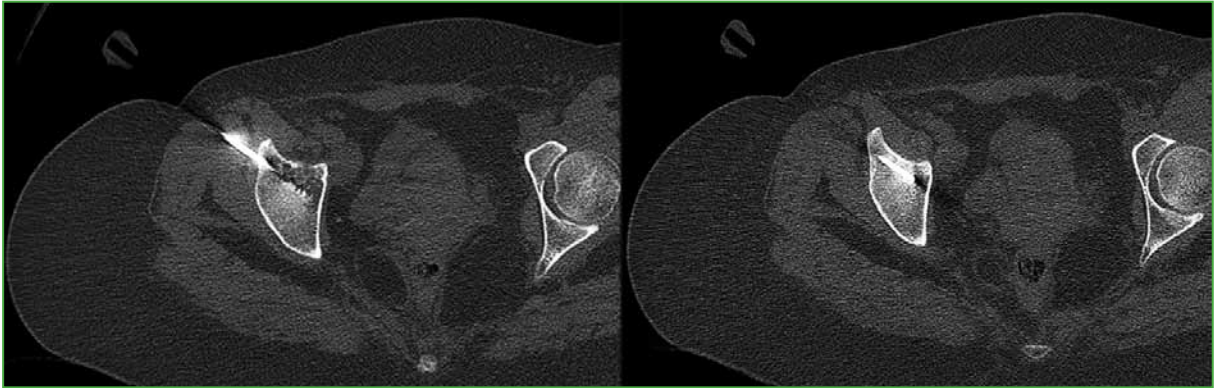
CT-guided biopsy at the level of the acetabulum.
